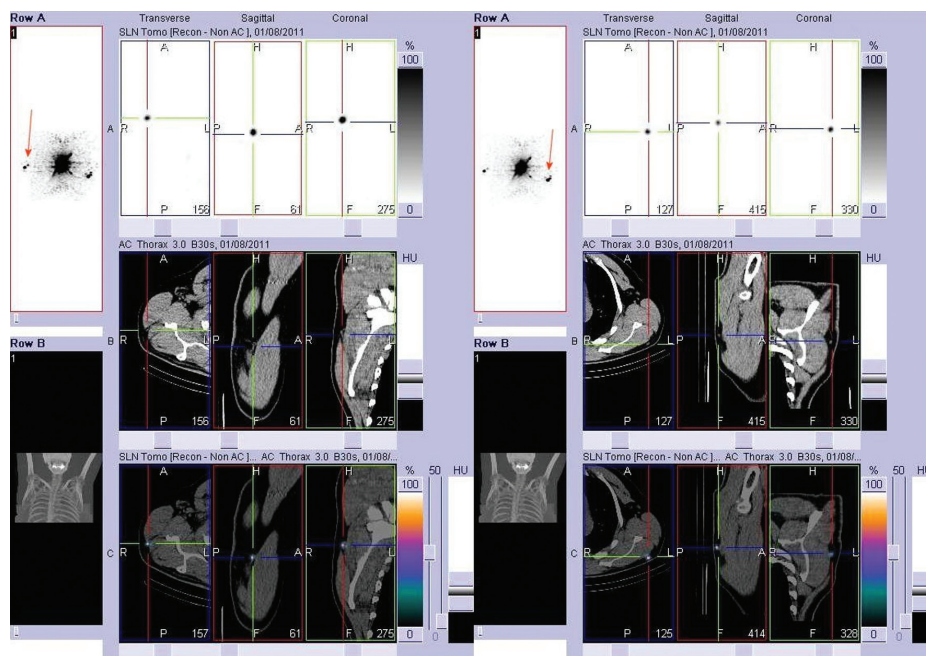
The same patient as in the figure 3. Fusion of SPECT and CT. Exact localization of two SLNs in the left axilla, and two SLNs in the right axilla
